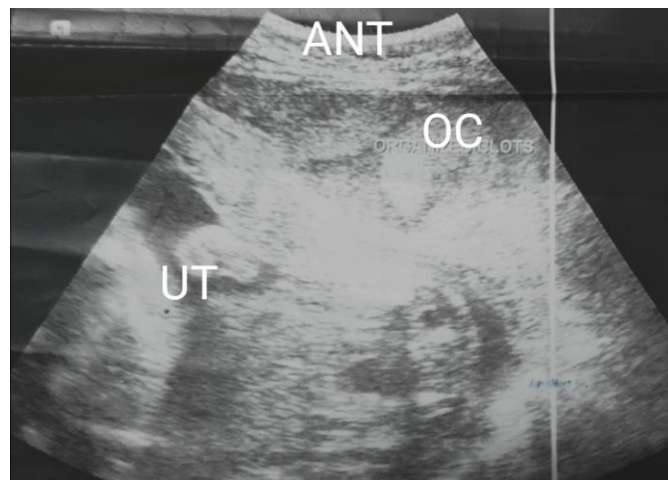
Pre-operative transabdominal ultrasound. ANT: Anterior. OC: Organized clots. UT: Uterus.
